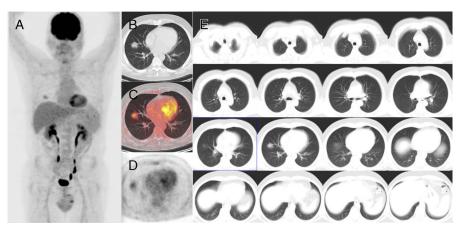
A 59-year-old man with diffuse large B-cell lymphoma on whom an ¹⁸F-FDG PET/CT was performed for immunochemotherapy response evaluation on March 18, 2020, 27 days after COVID-19 outbreak in Italy. Along with partial metabolic response, PET maximum intensity projection image (A) revealed a focal uptake area in the middle field of the right lung, corresponding on axial images (B, low-dose free-breathing coregistered CT; C, fused PET/CT; D, PET only) to a metabolically active (SUVmax 3.3) isolated centrilobular consolidation in the middle lung lobe surrounded by a faint ground-glass opacity (GGO) (maximum diameter 28 mm), without any other parenchymal alterations detectable bilaterally at coregistered CT (E). At that time, the patient was considered at low risk of SARS-CoV-2, ¹ being completely asymptomatic and denying suspected expositions to infected people. Based on clinical and morphofunctional characteristics, the PET/CT finding was interpreted as a nonspecific pneumonia at an early phase, as frequently occurring during chemotherapy. A subsequent clinical/radiological evaluation was suggested. On March 30, still asymptomatic without specific medication, the patient underwent a chest x-ray for revaluation, showing bilateral parenchymal consolidations, highly suggestive of viral pneumonia. He suddenly was tested for SARS-CoV-2 through nasopharyngeal swab, resulting as positive, and he was quarantined at home.
